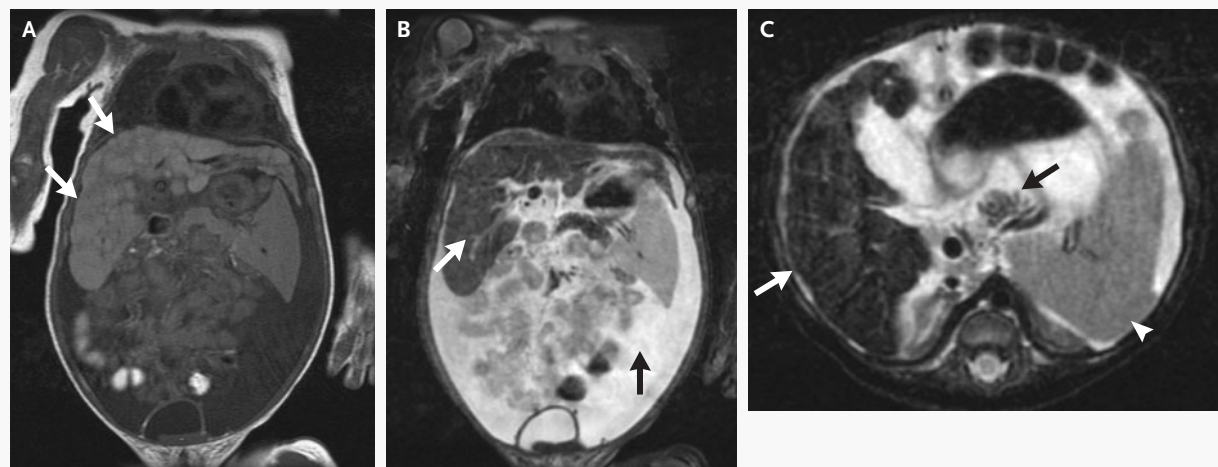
Magnetic Resonance Images of the Liver.
